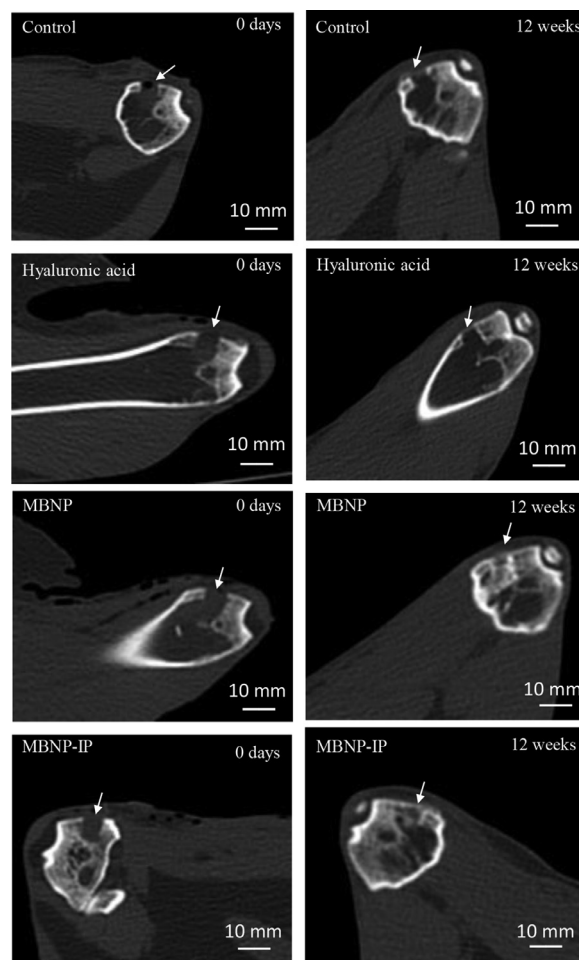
CT scan images obtained just after implantation (0 days) and after 12 weeks of study.
